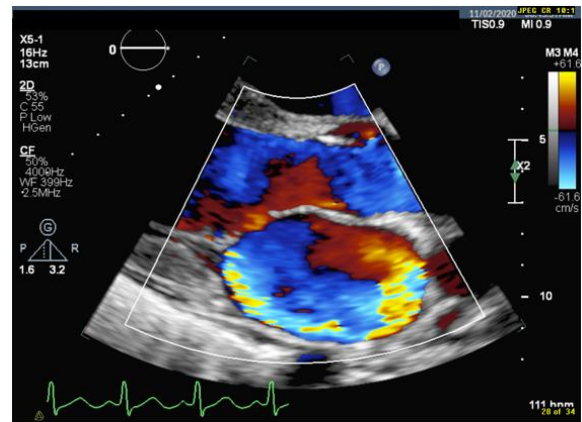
Transthoracic echocardiograph: Color Doppler image showing posteriorly directed eccentric mitral regurgitation of severe intensity by visual assessment.
